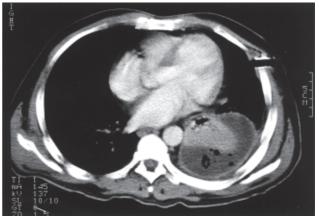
Computed tomographic scan of the thorax on initial admission
